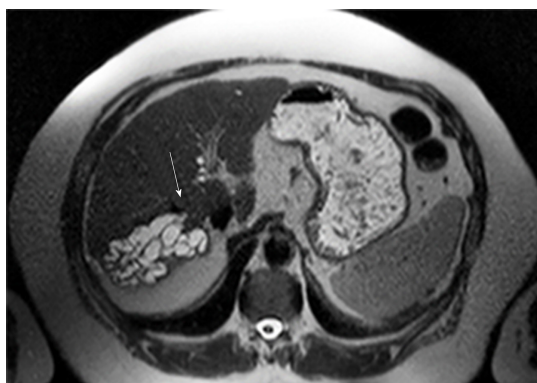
Transversal T2w magnetic resonance imaging of the liver of patient 2 who presented with segmental intrahepatic cholestasis caused by intrahepatic bile duct compression after transjugular intrahepatic portosystemic shunt. The arrow indicates the intrahepatic portion of the stent. Note the tubular structure with fluid typical high T2w signal converging in direct proximity of the transjugular intrahepatic portosystemic shunt which represents the congested, intrahepatic bile ducts of liver segment VII. The segments' liver parenchyma is completely extinct by the dilated ducts. Other causes for bile duct obstruction were ruled out by T1w with liver specific contrast.
